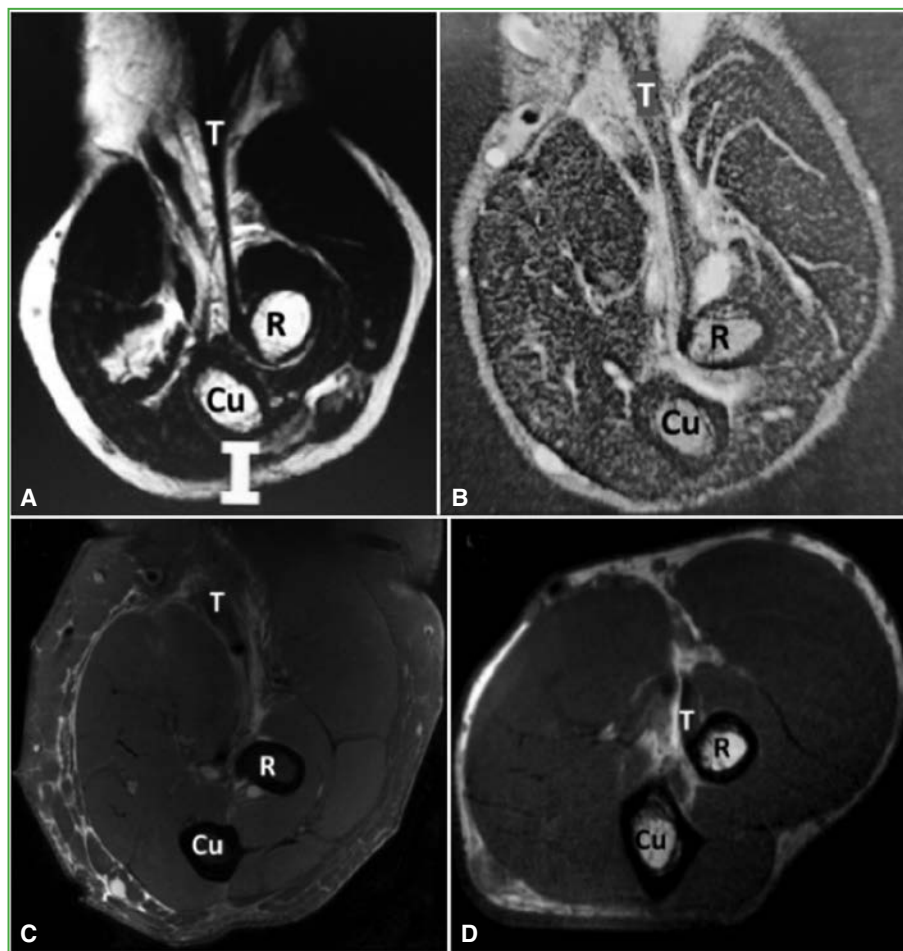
Magnetic resonance imaging of the proximal forearm, axial section at the level of the bicipital tuberosity, at different degrees of supination. A. 0° supination: normal insertion of the distal biceps tendon. B. 30° supination: partial tear of the distal biceps tendon. C. Maximum supination: complete avulsion of the distal biceps tendon. D. Reinsertion of the distal biceps tendon into the radial tuberosity using transosseous sutures in neutral pronosupination. Cu = Ulna; R = radius; T = distal biceps tendon.
